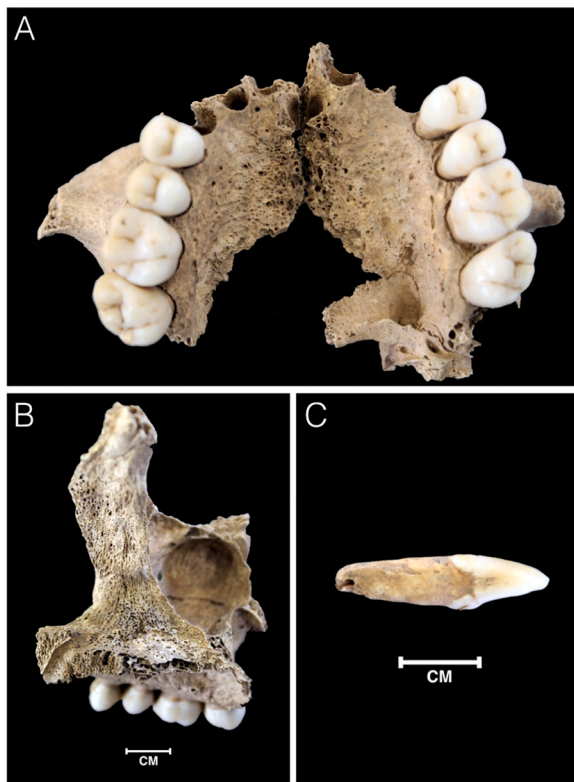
Detail of the rhinomaxillary area of individual UF 21 UE 1137 (male, 14–15 y.). A) Pitting on the palate. B) New bone formation on the nasal surface of the right portion of the maxilla. C) Periapical lesion on the right lateral upper incisor.
